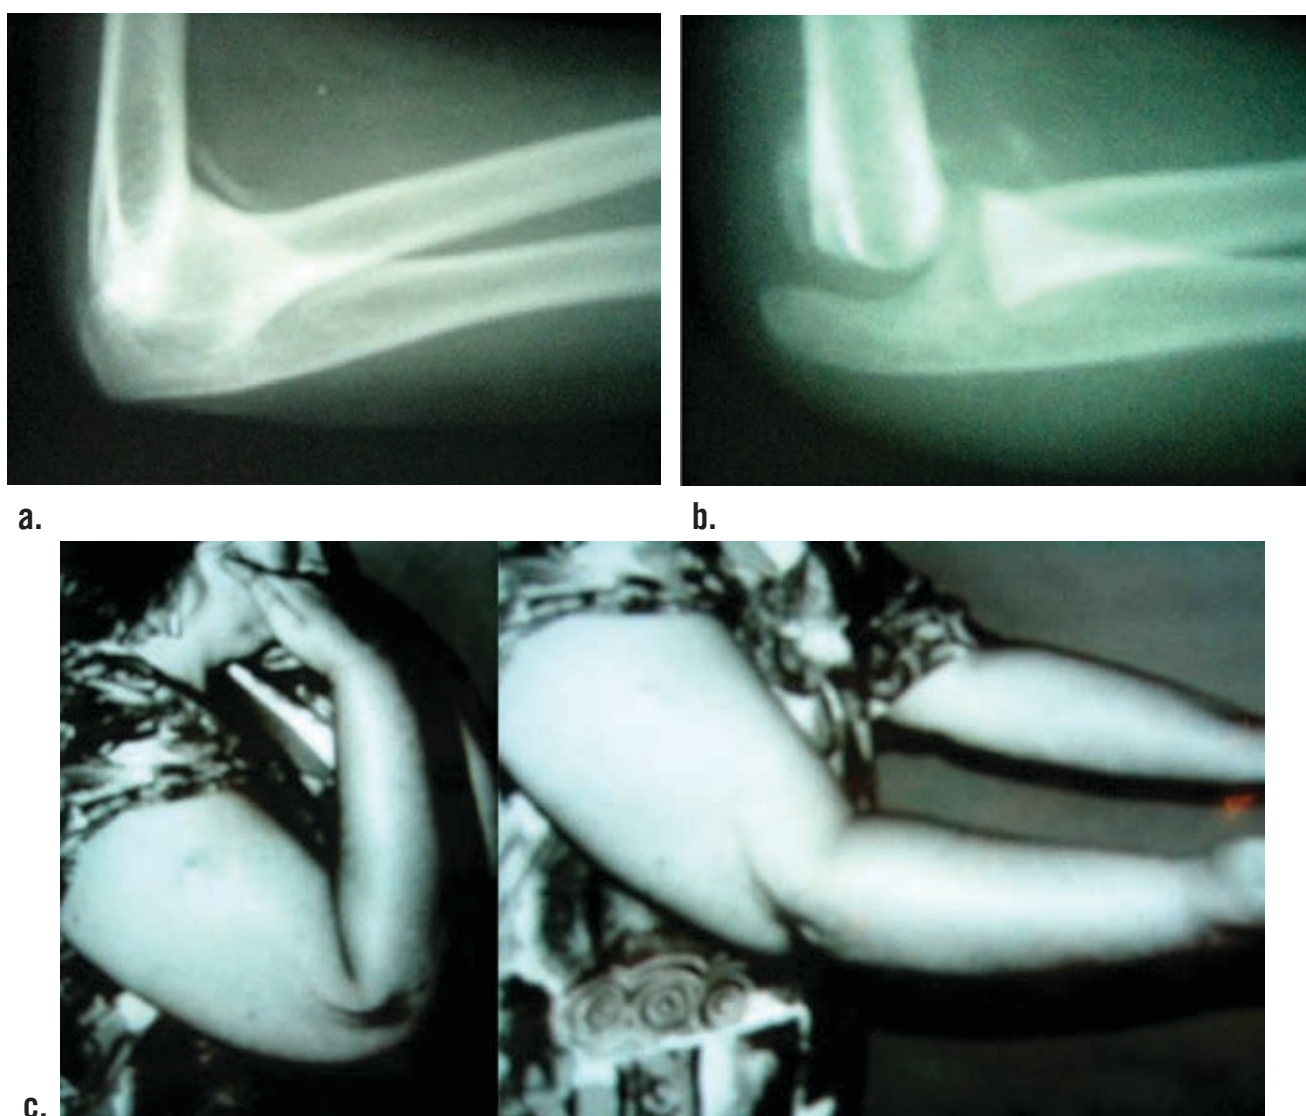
a - preoperatively X-ray; b - after resection X-ray; c - after resection amplitude of elbow mobility
